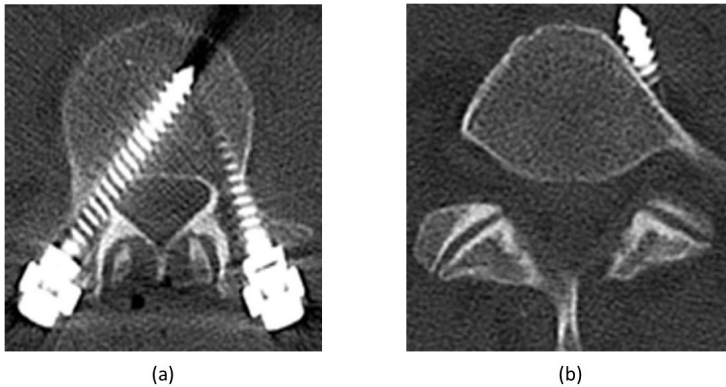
(a) CT scan showing an axial view of a right medially misplaced screw in L-4, which caused new on-set radiculopathy. Symptoms disappeared after screw replacement. (b) L-5 screw exceeding ventral cortex of vertebral body with close proximity to iliac vessel. Figure used with permission from [22].
